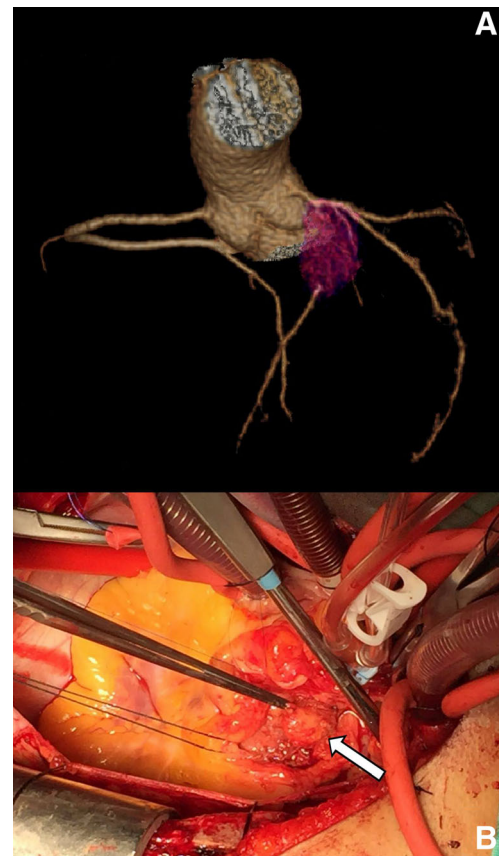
a Coronary computed tomography angiography (volume-rendering technique). The pseudotumor (*in purple*) is encasing the proximal segment of the left anterior descending coronary artery. Image courtesy of Dr. Karla Nuñez-Barragan and Prof. Guillermo Elizondo-Riojas, University Center for Diagnostic Imaging, University Hospital, UANL. b Intraoperative view before tumor excision. The *white arrow* denotes the location of the pseudotumor
